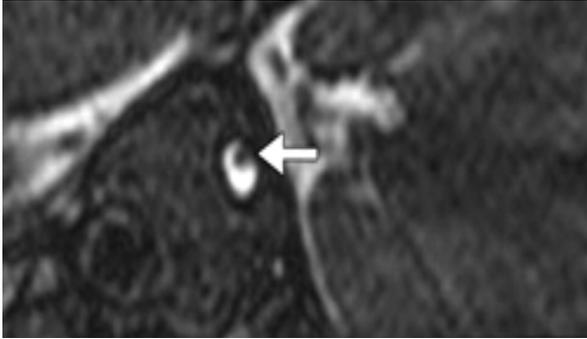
Sagittal MRI : single nerve within the IAC, suggesting absent 8th nerve
